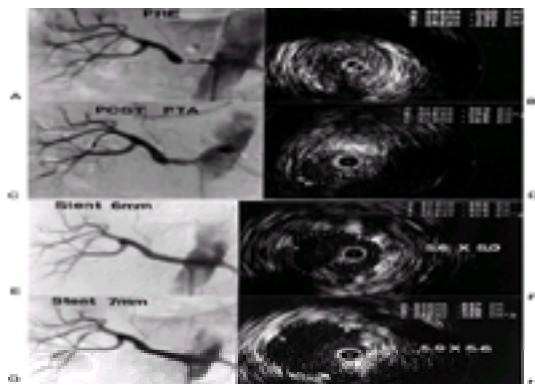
PTA of proximal renal artery lesion, guided by intravascular ultrasound (IVUS). A: Baseline angiogram depicts severe proximal renal artery stenosis. B: Corresponding IVUS image shows plaque abutting catheter circumferentially. C: Post-PTA, irregular lumen with plaque fracture and residual stenosis. D: IVUS post-PTA shows only modest enlargement of lumen. E: Deployment and dilation of Palmaz stent with 6-mm balloon; angiographic result much improved over PTA alone. F: IVUS shows doubling in lumen diameter over PTA alone. However, in spite of excellent angiographic appearance, IVUS shows that diameter of treated segment is still less than “reference segment.” G: After inflation with 7-mm balloon, the angiographic result is slightly better. H: IVUS now shows that the size of the stented vessel is equal to that of the reference segment. This case highlights the utility of IVUS in renal angioplasty.
